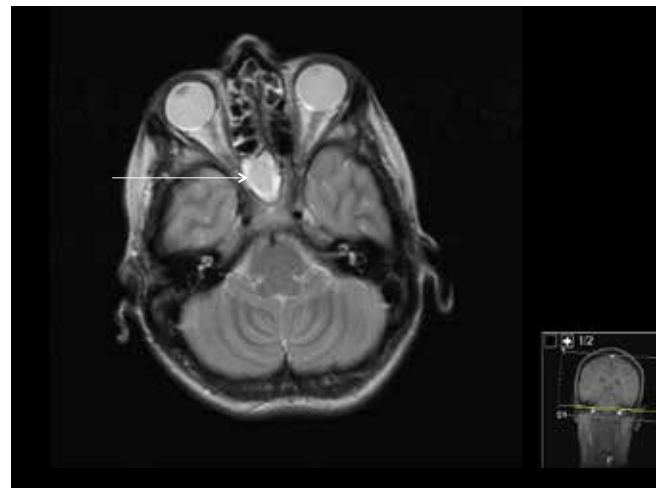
A lady in mid-twenties who previously attended neurology with frequent migraine. Presented with new daily persistent headache of several weeks duration like a severe pressure in her head and preventing sleep. Completely unlike previous migraine. MRI Head shows total opacification of right sphenoid sinus (arrow). Her new headache was relieved after surgical treatment, but episodic migraine continued
